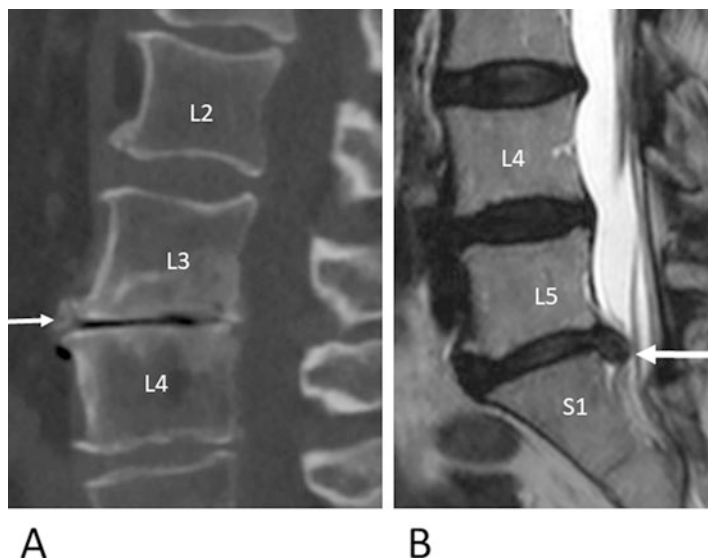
A mid-sagittal CT scan (a) and MR image (b) of the lumbar spine showing the features of disc degeneration: loss of disc height and anterior osteophytes (a, white arrow) and disc herniation (b, white arrow). Note the difference in disc height between L2–L3 (healthy disc) and L3–L4 (degenerated disc) in (a). L2–L5, second to fifth lumbar vertebra; S1, first sacral vertebra
